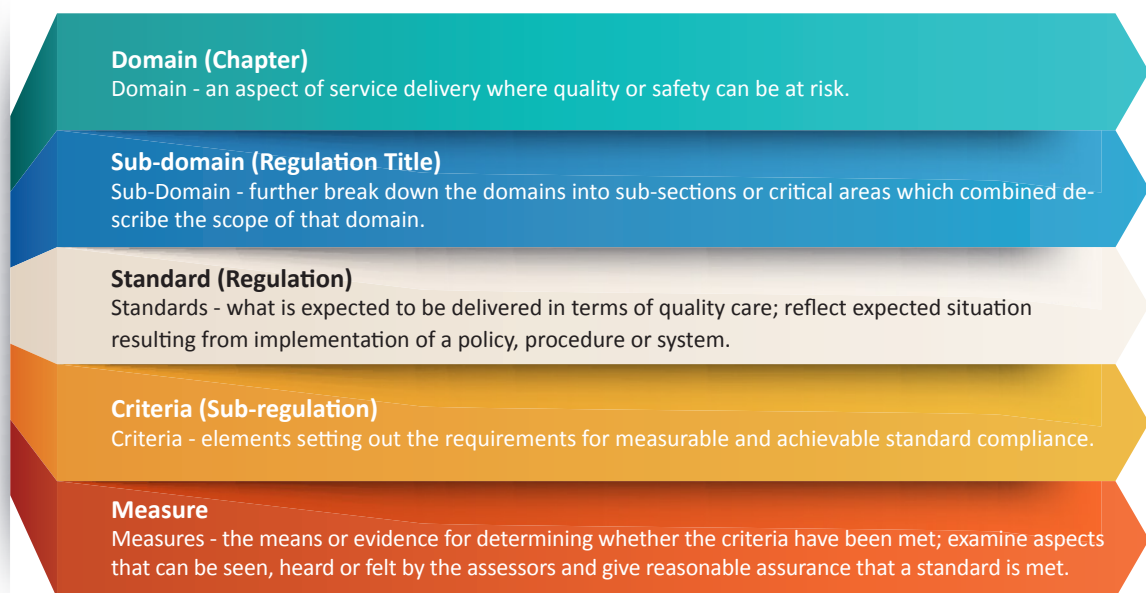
STRUCTURE OF THE INSPECTION TOOLS
